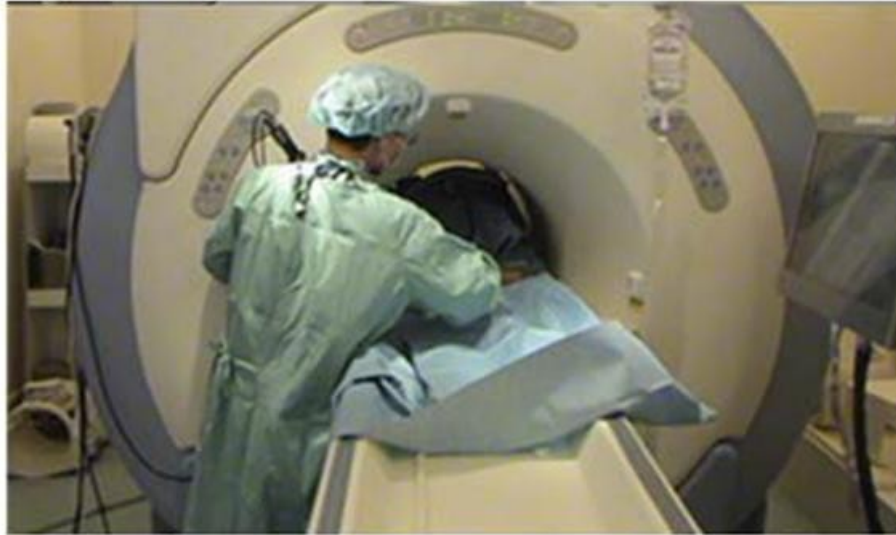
Spatial constraints posed by flexible endoscopy inside closed-bore MRI scanners [Naka, 2012].
